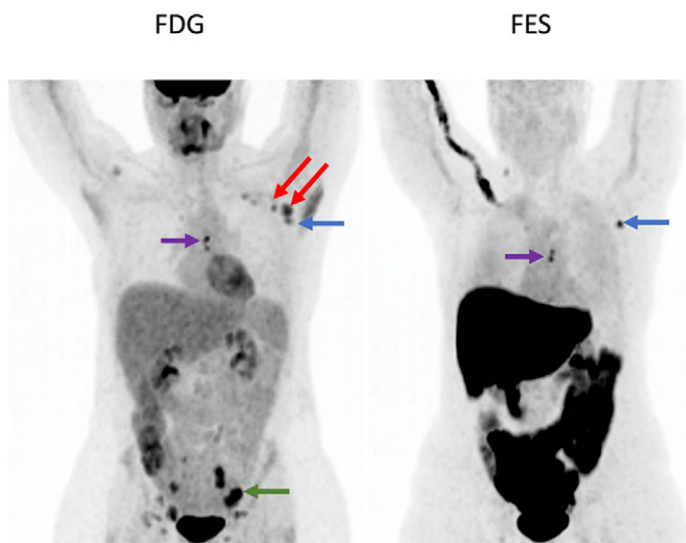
Metastatic ER-positive invasive ductal carcinoma and equivocal FDG-avid findings in a 44-year-old woman. Coronal MIP FDG PET image (left) shows abnormal FDG uptake in the left axillary lymph nodes (red and blue arrows, left), the internal mammary lymph nodes (purple arrow, left), and the pelvic nodes (green arrow). Coronal MIP FES PET image (right) shows abnormal FES uptake in a single left axillary lymph node (blue arrow, right), which showed ER-positive metastasis at biopsy, and in the internal mammary lymph nodes (purple arrow, right), which is consistent with ER-positive disease, but no abnormal FES uptake in the high axillary lymph nodes or the pelvic nodes. One of the high axillary lymph nodes (red arrows, left) showed reactive changes at biopsy. Because reactive or inflammatory changes are not FES avid, abnormal FES uptake in lymph nodes is highly specific for FES-positive, functionally ER-positive metastasis. Thus, FES PET allows clarification of indeterminate FDG findings (SUV scale, 0–5).
